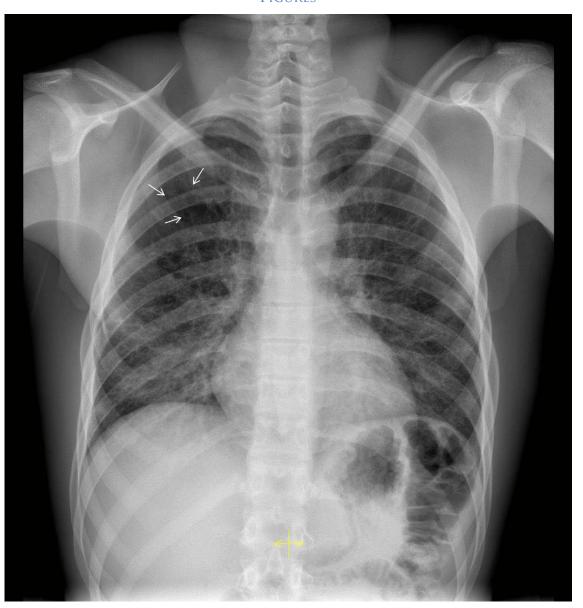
Chest radiography with postero-anterior incidence demonstrating cystic structures distributed diffusely in the upper and mid lung and more prominent on the right upper lung (arrows).
